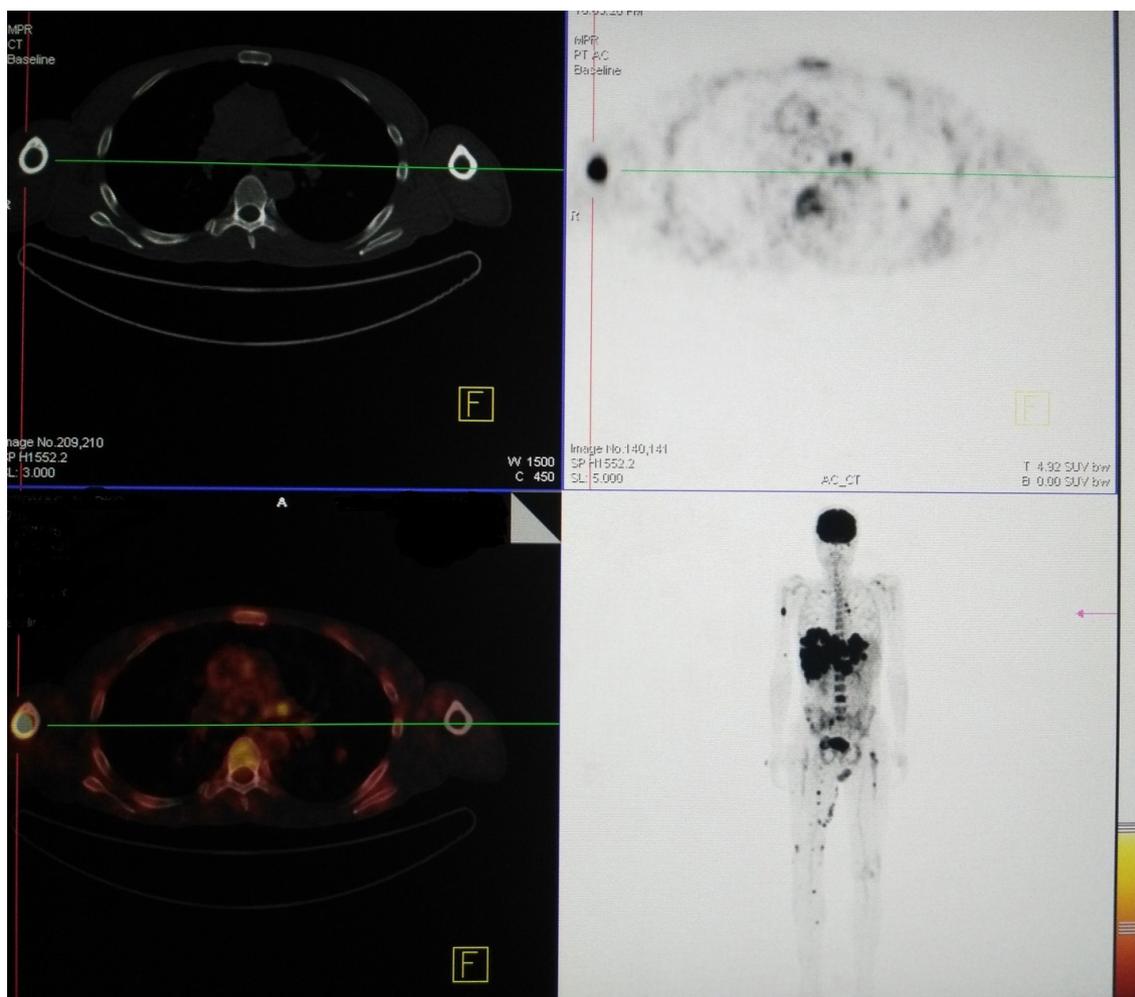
18F-FDG PET / CT revealed disseminated disease and upstaged disease in this 64 years old patient. The disseminated disease on MIP (maximal intensity projection image), the active disease is present in the right humerus, mediastinal lymph nodes, liver and other bones (vertebrae, iliac bone, femur). High metastatic burden resulted in early death, 4 months after the 18F-FDG PET/CT examination.
